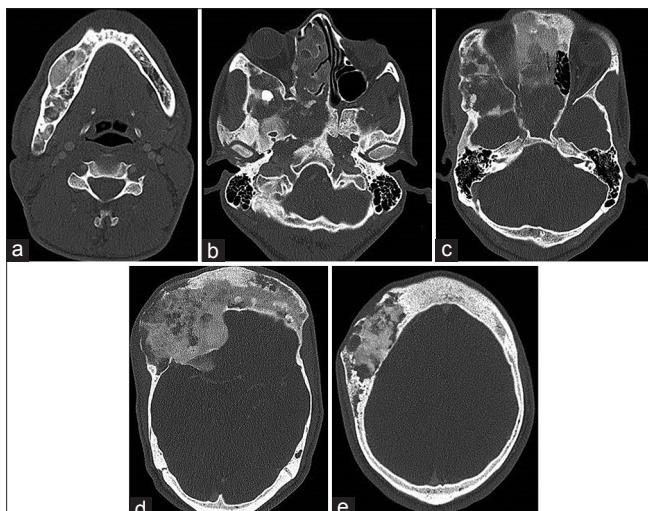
Demonstrated the axial view of CT scan (a) right mandible bone, (b and c) right skull base involvement, (d and e) right and left frontal bone involvement
